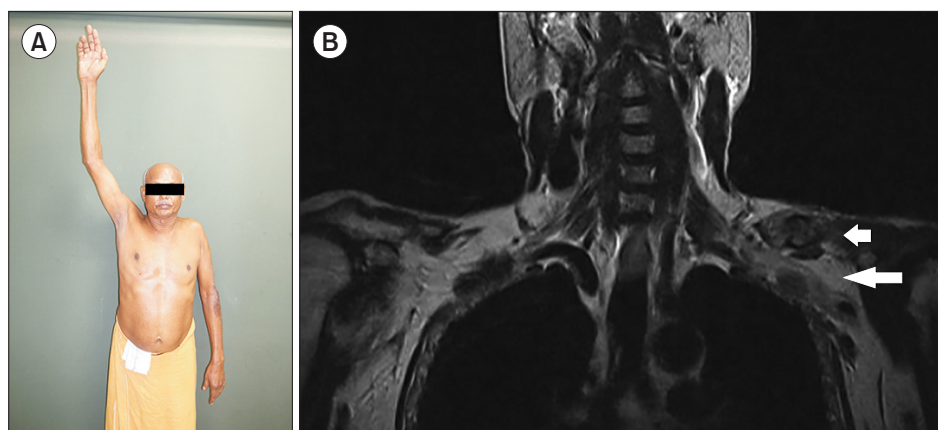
(A) Clinical photograph of patient preoperatively demonstrating inability to actively abduct the left shoulder. (B) Magnetic resonance imaging of the brachial plexus showing hypertrophic callus at the clavicle nonunion site (short arrow) immediately adjacent to the infraclavicular brachial plexus (long arrow).
